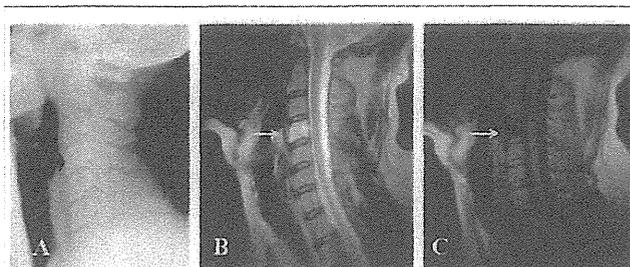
Cervical spine X-ray and sagittal cervical MRI of case 2. Cervical spine X-ray (A), T2-weighted (B), and T1-weighted (C) images on admission. Black arrow indicates mild hyperintensity in C4 (A). White arrows indicate prominent T2 high and T1 low intensity signals in C4 without abscess formation (B and C).
